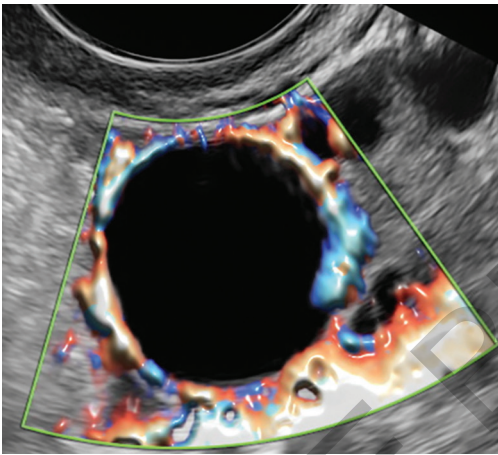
Color Doppler of mature follicle.
